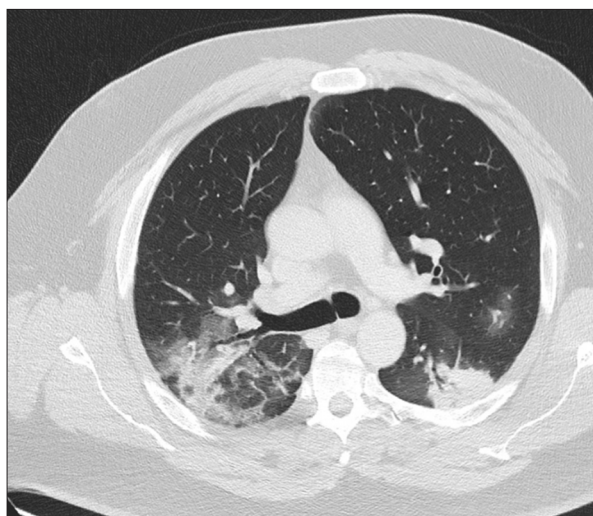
Chest computed tomography on admission, showing bilateral infiltrates.
